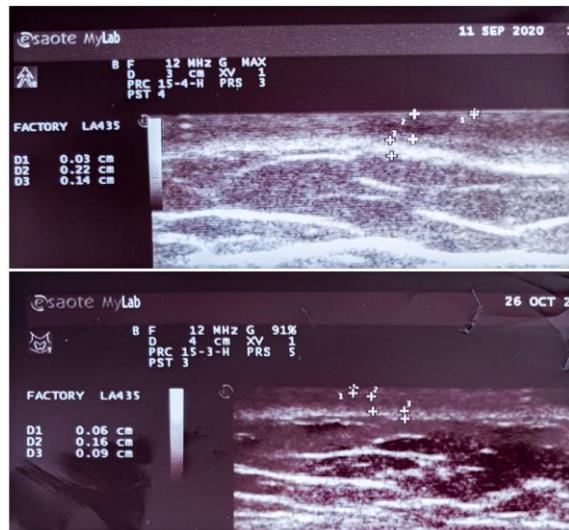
Ultrasound measurement before and after HIFU treatment.
